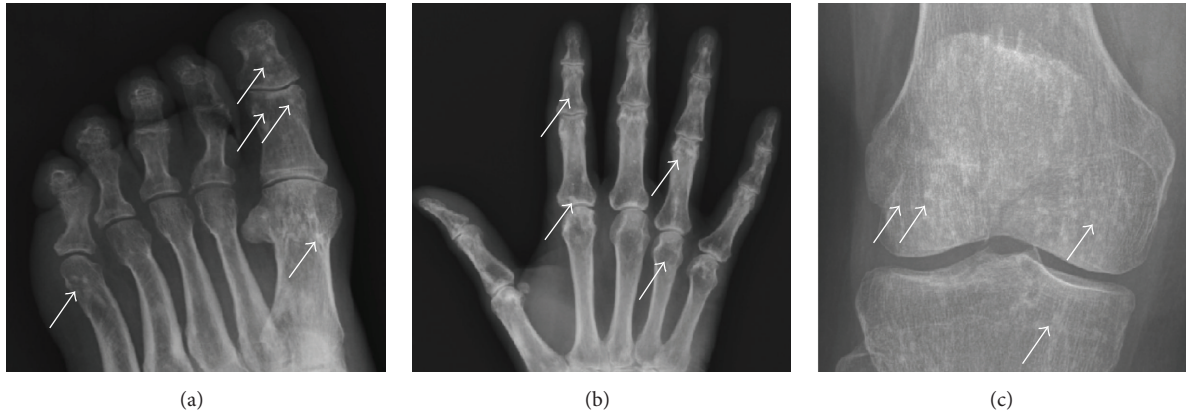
Osteopoikilosis. Plain radiographs. (a) Foot. (b) Hand. (c) Knee. Note multiple small (1–5 mm) sclerotic periarticular lesions consistent with bony islands of osteopoikilosis (marked by arrows).
